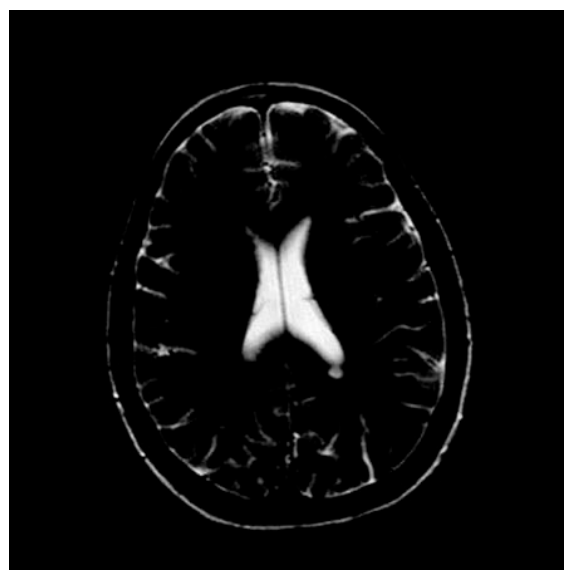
Axial T2-weighted image showing a left parietal ovoid periventricular lesion (of 16 overall lesions), from subject 1.
